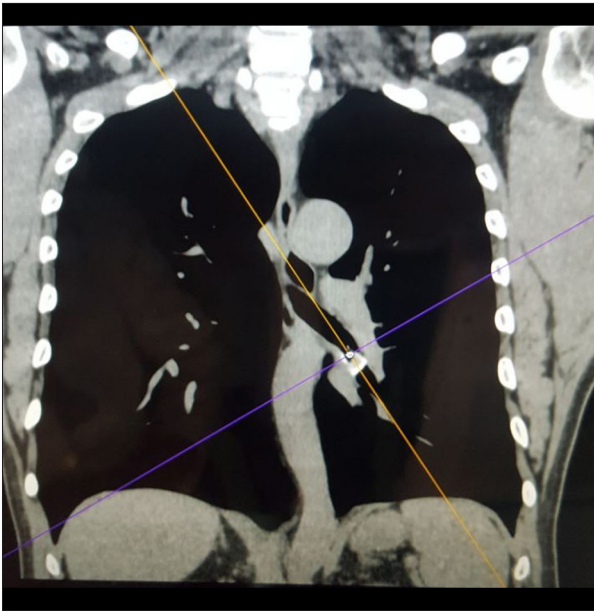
Non-contrast CT scan of the chest demonstrating a radiopaque structure located inside the left main bronchus, with bone-like density.
